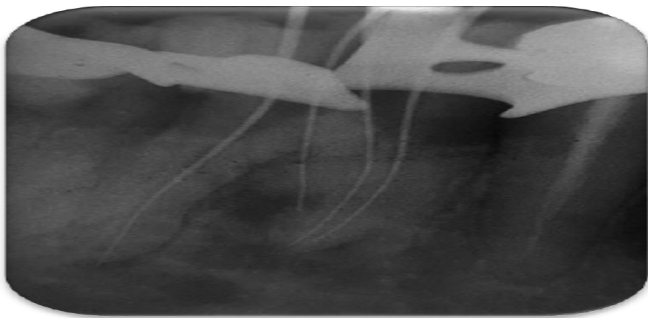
Radiography with K files on the canal of the 46
